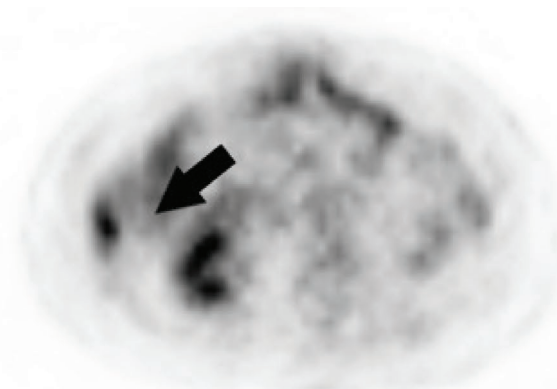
Second PET-CT scan after beginning of pembrolizumab and lenvatinib shows both morphological stability and a favourable metabolic response. Arrow indicates metabolic response of hepatic nodule shown in Figure 1.
